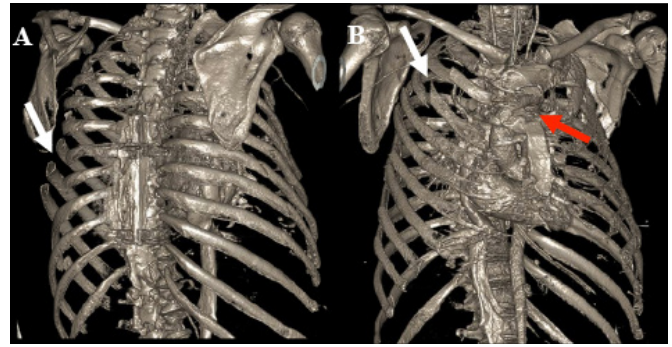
The images above depict three-dimensional renderings of the patient's axial skeleton adapted from CT scan. The white arrow in A shows lateral fractures to left-sided ribs 6, 7, 8, which were reduced and fixated during surgery with titanium plating. The white arrow in B shows right-sided anterolateral rib fractures to ribs 2 and 3, which were also reduced and fixated during surgery using titanium plating. The red arrow in B depicts the large disunion of the manubrium and sternal body from one another, which was reduced and fixated using titanium plating through sternotomy.
